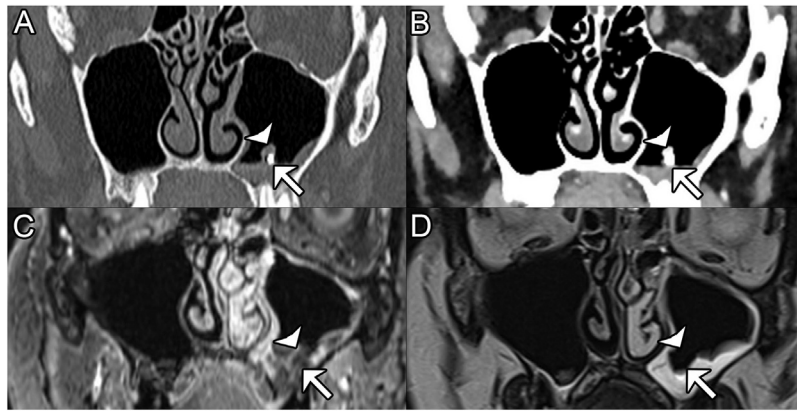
Just visible maxillary fungus ball: coregistered CT-scanner (A, B) and T1 with gadolinium (C, axial 3DVibe gradient recall after 2D reslicing in the coronal plane coregistered with T2), T2wi (D). Metal dental filling (arrow) migrated into the maxillary sinus cavity is shown on CT using bone windowing in bone algorithm. Very small-sized fungus ball (arrow head) is seen as a dense lesion above the dental amalgam on CT with soft tissue algorithm and windowing (B), containing secretions in signal void T2 (D) compared to T1 (C). Note the absence of micro-concretion seen on CT with bone algorithm (A).
